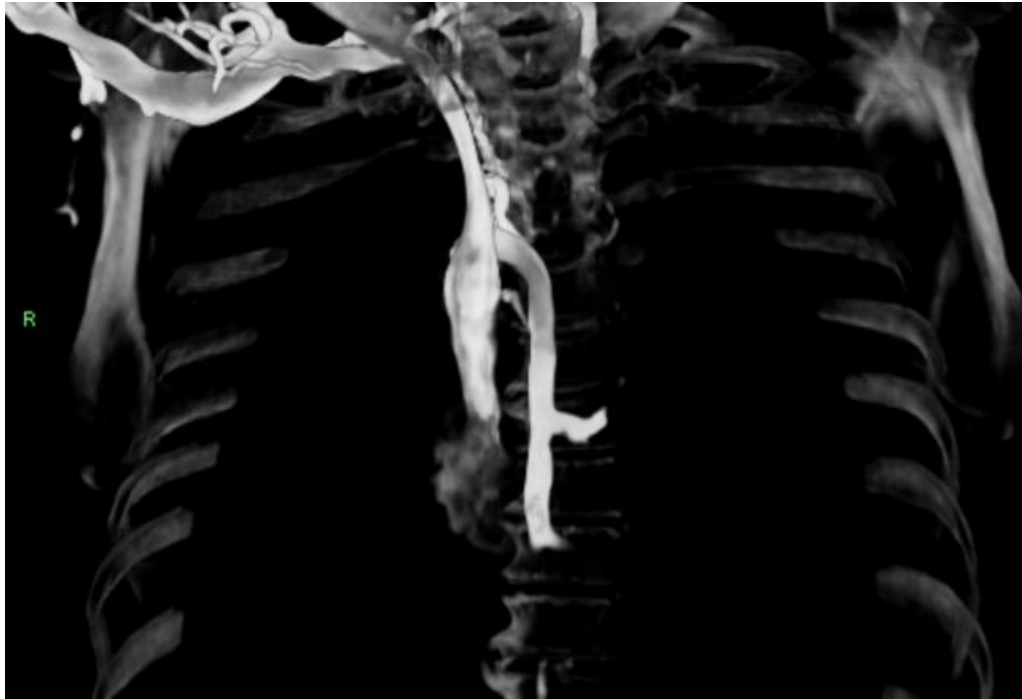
RADIOGRAPHIC IMAGE SHOWING THE AZYGOS VEIN AND ITS TERMINATION INTO THE SUPERIOR VENACAVA
